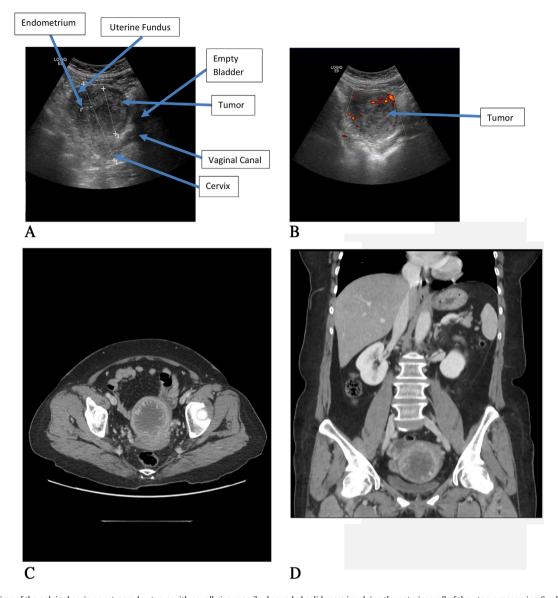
A Sagittal view of the pelvis showing a retrograde uterus with a well circumscribed rounded solid mass involving the anterior wall of the uterus measuring 6×5.5 cm and seen to exert a mass effect on the cavity stripe, with posterior displacement. B Axial image from a power Doppler study of the uterus showing peripheral vascularization with a coarse heterogeneous echotexture of the uterine mass. C Axial CT scan of the pelvis showing a $5.6 \times 5.5 \times 5.3$ cm centrally hypo-attenuating well defined intra-cavitary uterine mass with peripheral enhancement. D Coronal CT scan of the pelvis showing a $5.6 \times 5.5 \times 5.3$ cm centrally hypo-attenuating well defined intra-cavitary uterine mass with peripheral enhancement.
